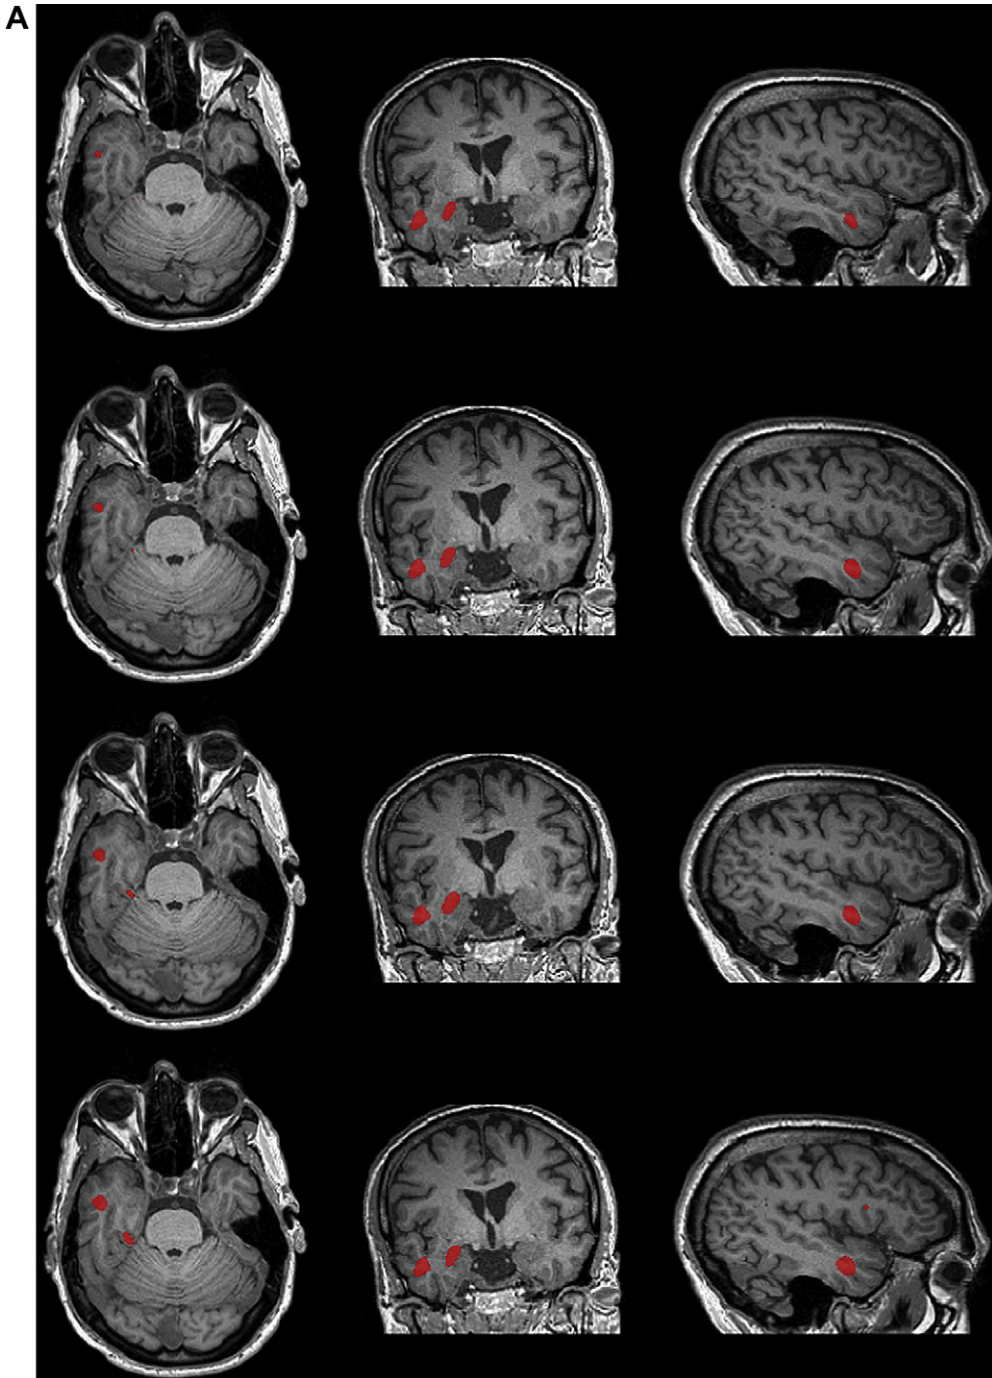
Representative slices of a patient showing an example of SPECT/PET and MR imaging registration and fusion for the evaluation of epilepsy. Two ^{99m}Tc -ECD scans performed during seizure (ictal) and when the patient was seizure free (interictal) the following day are shown. Both SPECT studies and a three-dimensional, T1-weighted MR imaging study were coregistered using the normalized mutual information criterion. (A) The differences between the ictal and interictal SPECT studies are overlaid on transaxial slices of the MR imaging study to permit accurate localization of the focus of the epilepsy. (B) A coregistered FDG-PET study superimposed on the MR imaging study is also shown.
